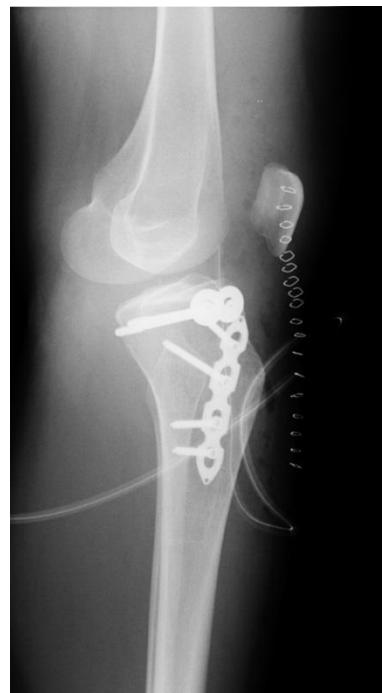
Lateral postoperative X-ray
